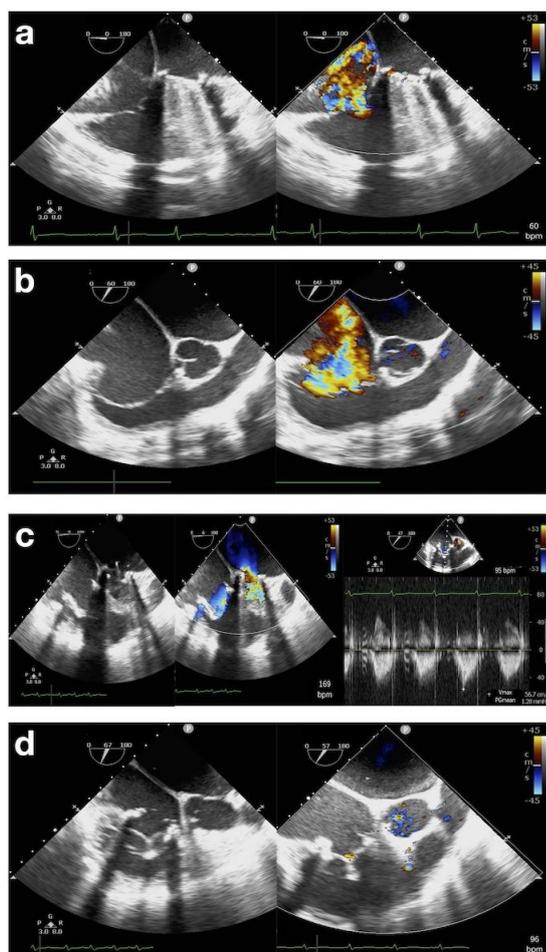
(a-b) Preoperative transthoracic echocardiography revealed severe tricuspid regurgitation and a normally functioning mitral prosthesis: (a) mid-esophageal four-chamber view, (b) right ventricle inflow-outflow view. (c-d) Postoperative transthoracic echocardiography showed good bioprosthetic tricuspid valve function in (c) diastole and (d) systole (bpm = beats/min).
